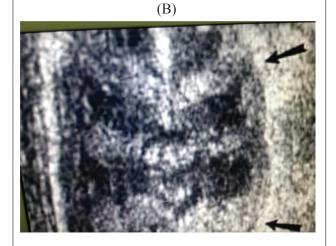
An ultrasound image of adrenal glands showing an enlarged, lobulated with maintained normal corticomedullary differentiation (A). It has a "cerebriform" appearance (B) in a newborn with congenital adrenal hyperplasia due to 21 hydroxylase deficiency.
